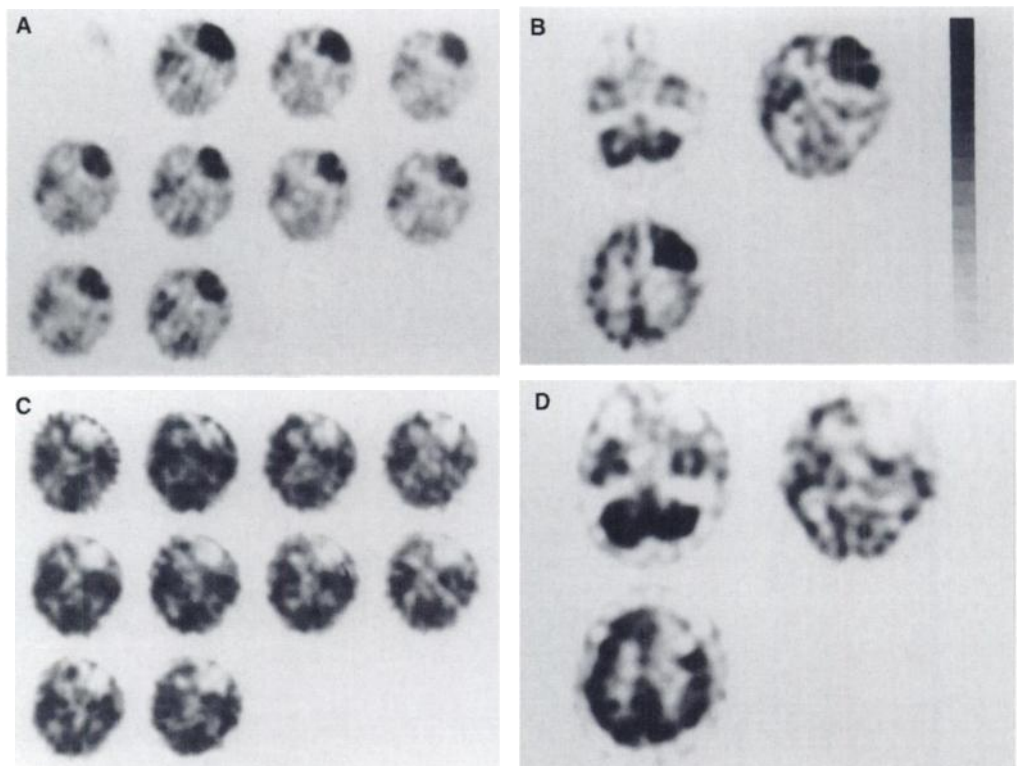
Technetium-99m-ECD brain SPECT images before (A, B) and after (C, D) partial tumor resection. Technetium-99m-ECD dynamic images demonstrate increased and relatively homogeneous accumulation throughout the tumor (A). Static images also show relatively homogeneous accumulation in the tumor (B). After surgery, dynamic (C) and static (D) images show a large area of decreased uptake in the right frontal lobe.
